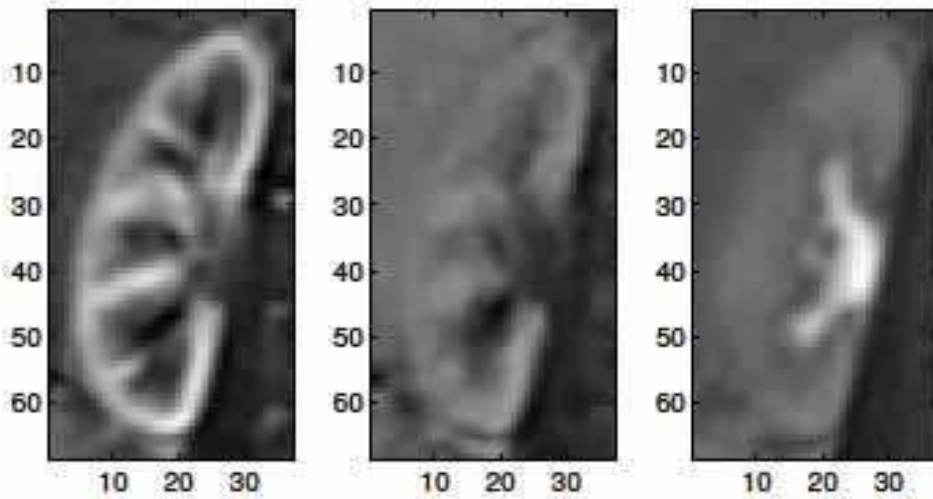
Examples of frames from a DCE-MRI sequence during arterial peak (left), filtration (middle) and late phase (right)
